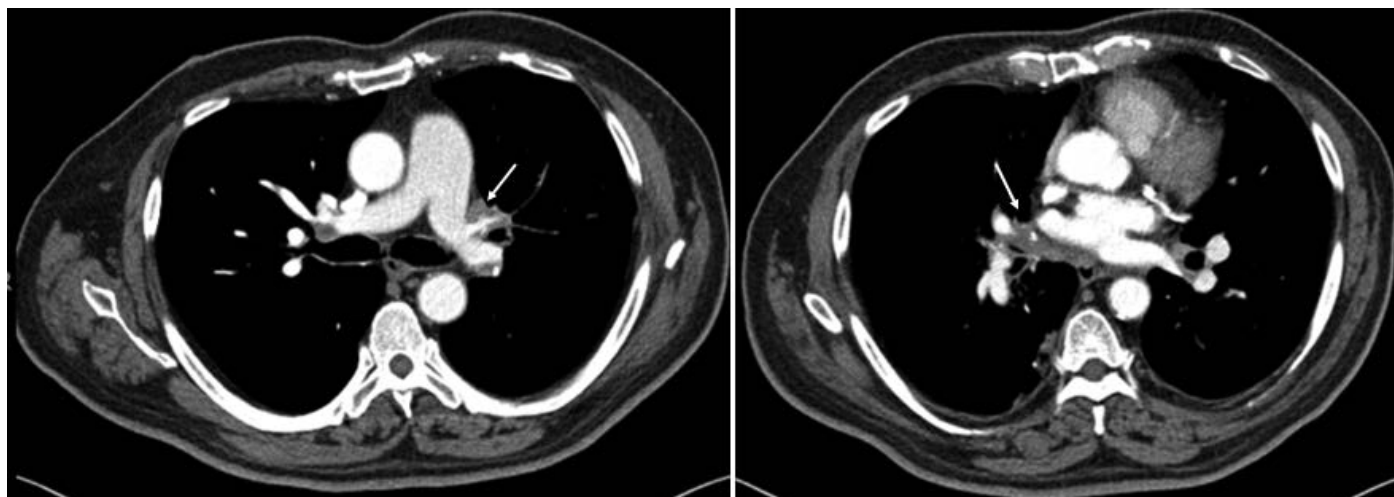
78-year-old male with fibrosing mediastinitis complicated by pulmonary hypertension. Computed tomography images demonstrating infiltrative soft tissue with calcium deposits and consequent multifocal narrowing of the pulmonary arteries, veins, and bronchi.
